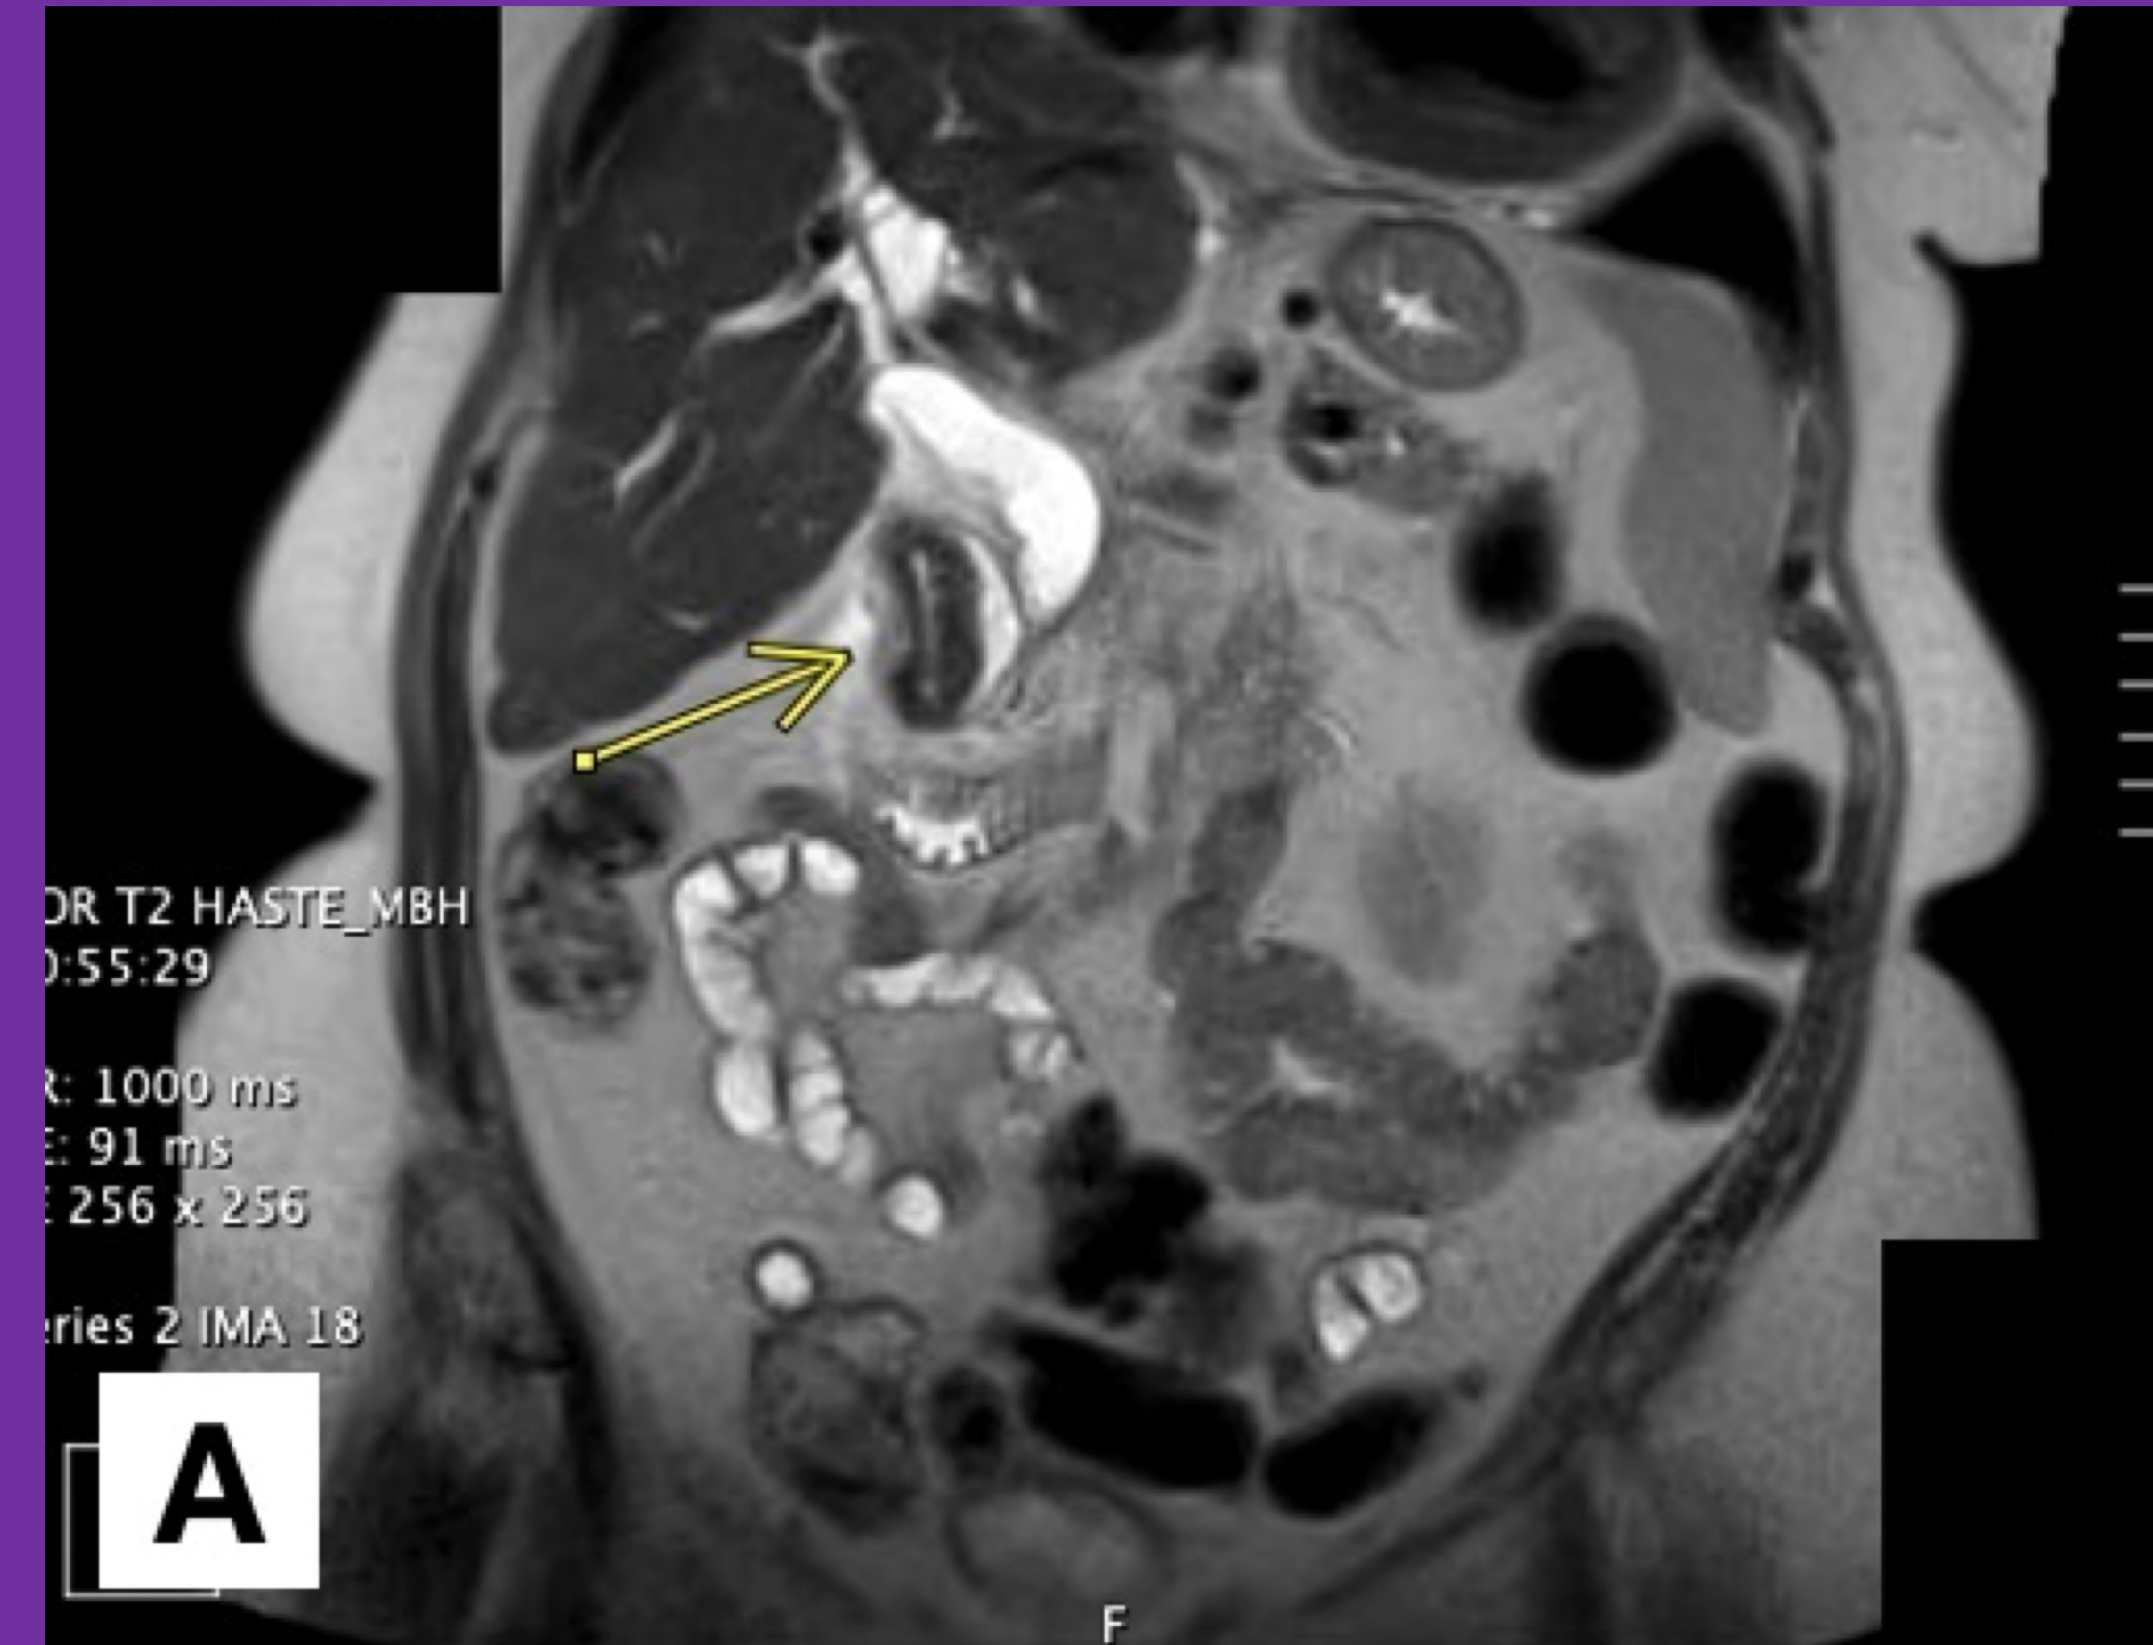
Coronal slice from MRI abdomen and pelvis demonstrating a large periampullary duodenal diverticulum with obstruction of the common bile duct.
